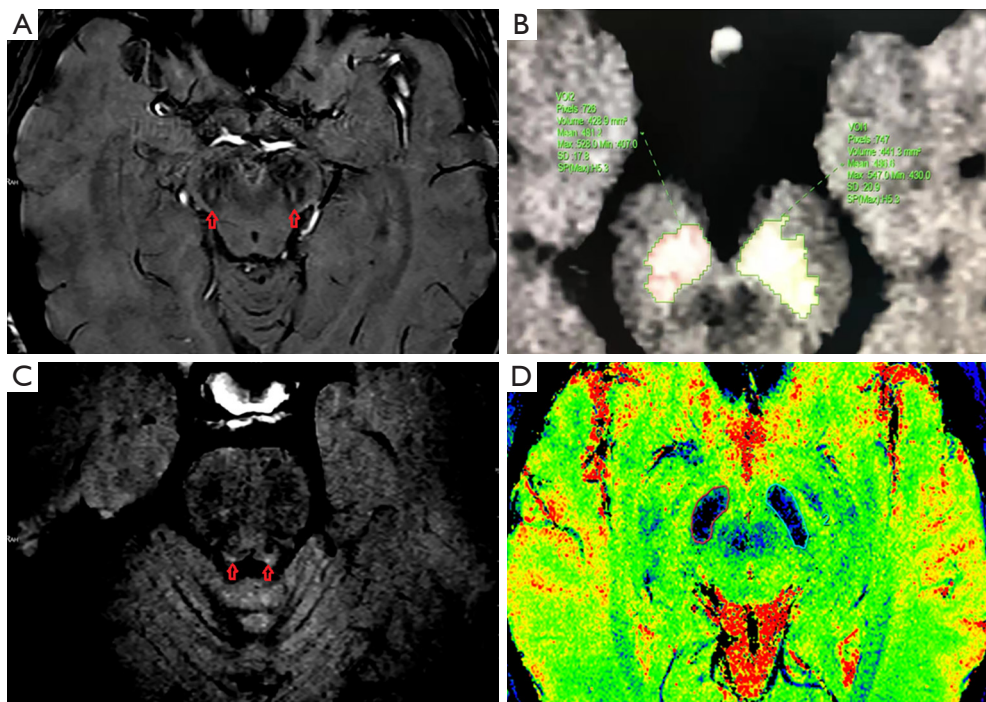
Display of the substantia nigra and locus coeruleus regions and corresponding indicator observations based on multiple MRI sequences. (A) Swallow tail sign displayed on SWI (the area is indicated by the red arrows). (B) The distribution of melanin in neurons of bilateral substantia nigra on NM-MRI (green outlined area). (C) The high signal intensity in bilateral locus coeruleus nuclei on NM-MRI (the red arrows indicate the high signal area). (D) The bilateral substantia nigra areas were outlined, and T2* and R2* values were obtained based on T2* mapping (dark blue area outlined by the wireframe). VOI, volume of interest; SD, standard deviation; SP, scale pixel; MRI, magnetic resonance imaging; SWI, susceptibility-weighted imaging; NM-MRI, neuromelanin-sensitive magnetic resonance imaging.
